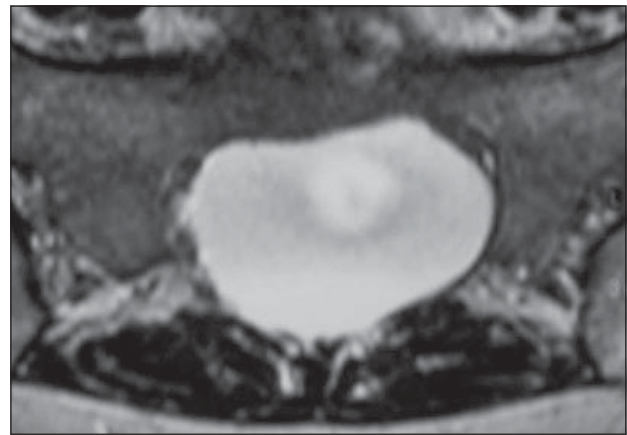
T2-weighted magnetic resonance imaging with axial scan of the sacral region demonstrating dural ectasia.
